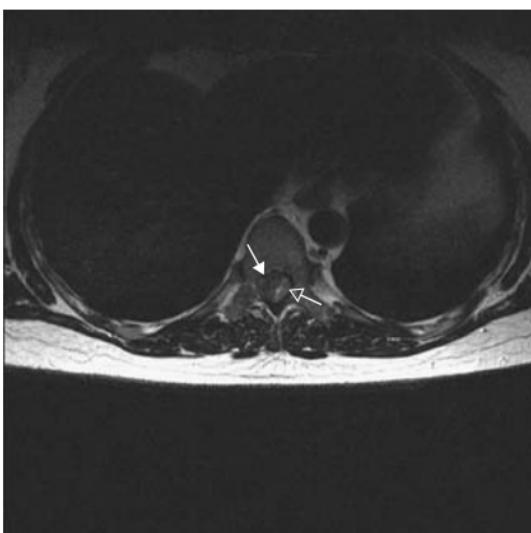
Thoracic spinal meningoma. (a) Post-contrast enhanced sagittal and (b) axial T2W MRI. Homogenously enhancing intradural extramedullary mass at T10 (closed white arrow) with a relatively broad dural attachment ((a) open white arrow). The spinal cord is compressed and displaced to the posterolateral aspect of the vertebral canal ((b) open white arrow).
